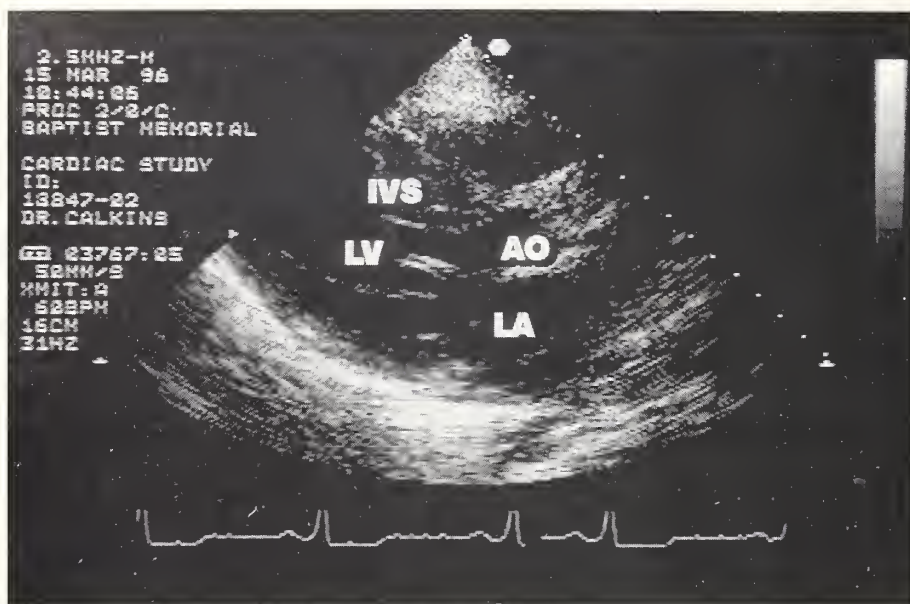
Parasternal long axis echocardiogram demonstrating asymmetrical septal hypertrophy of the intraventricular septum, systolic anterior motion of the anterior mitral valve and marked left atrial dilatation.
